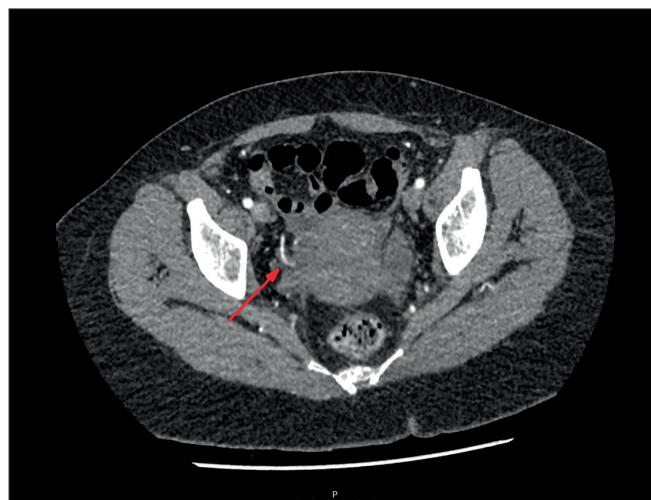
Arterial phase of CT angiogram showing extravasation of contrast from a branch of the right uterine artery (red arrow) into the endometrial cavity.
